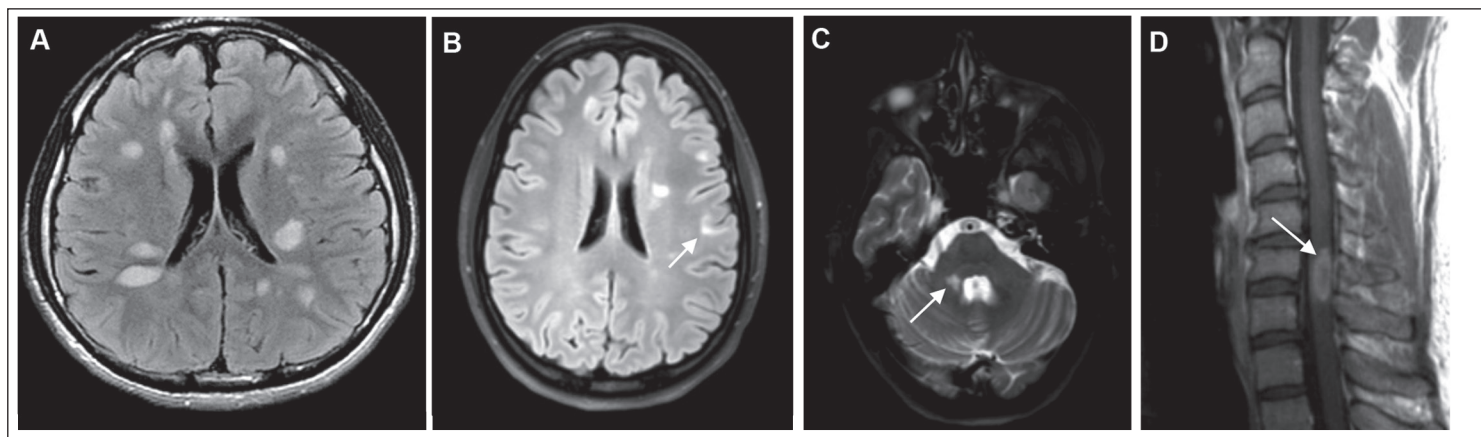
Brain and cervical spine MRI showing a "typical" appearance and location of MS lesions. (A) T2-fluid-attenuated, inversion recovery (FLAIR) sequence showing typical periventricular lesions are seen each measuring greater than 3 mm in diameter, generally ovoid in appearance and oriented perpendicular to callosal plane corresponding to the course of venules. (B) T2-FLAIR sequence showing juxtacortical lesion involving cortico-cortical connecting fibers. (C) T2 sequence showing lesion involving the right middle cerebellar peduncle (infratentorial lesion). (D) Post-contrast T1 sequence showing enhancing cord lesion
